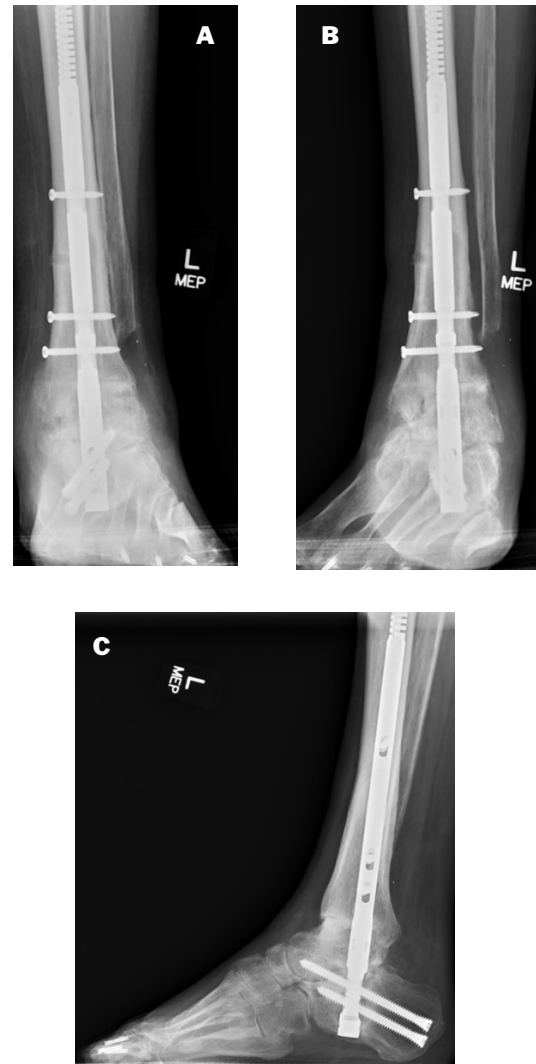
(A-C): Three WB ankle radiographs 5 months post op showing maturing signs of fusion across the ankle and subtalar joints and union of the tibial osteotomy. A. AP view B. Mortise view C. Lateral view
